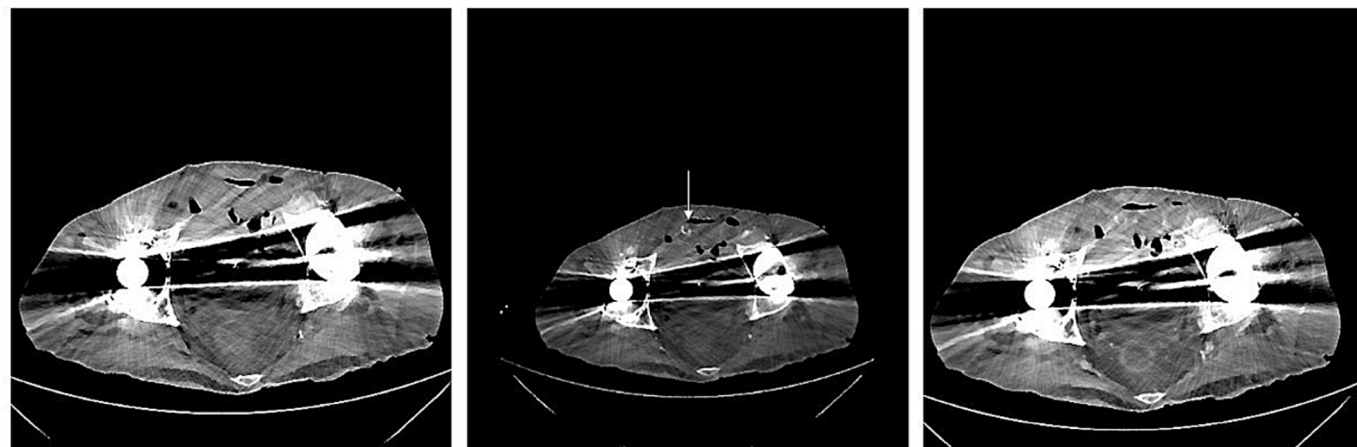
Case 3: Axial slice from a CT of the pelvis in non-contrast (left image), arterial phase (middle image) and portal venous phase (right image). Non-contrast scan was assessed as helpful to be able to reliably evaluate the intraluminal arterial phase hyperdensity (white arrow) in a distal jejunal loop, that showed no venous pooling, as contrast extravasation, as it was not present in the non-contrast scan.
